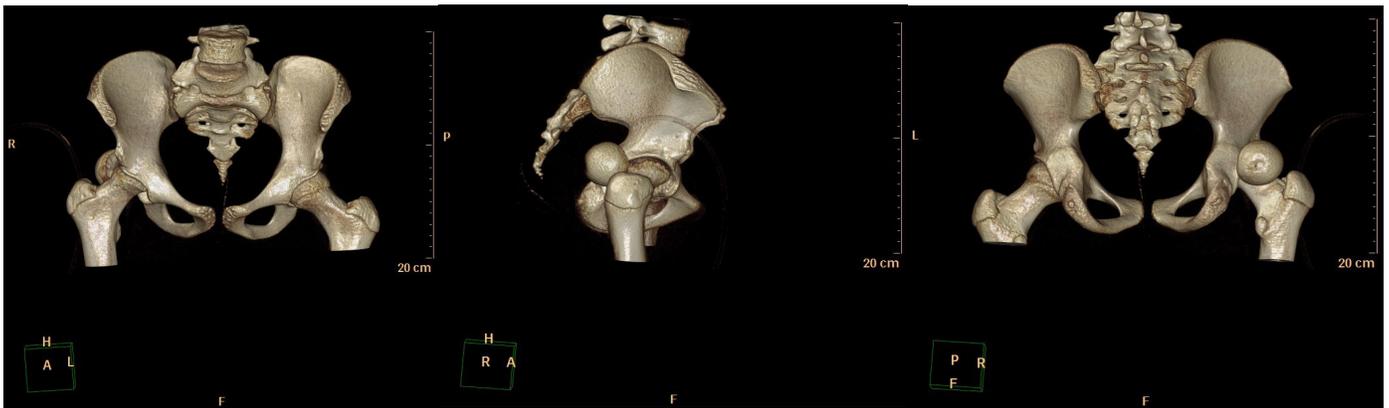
CT scan images below were done to assist with pre-op planning.
